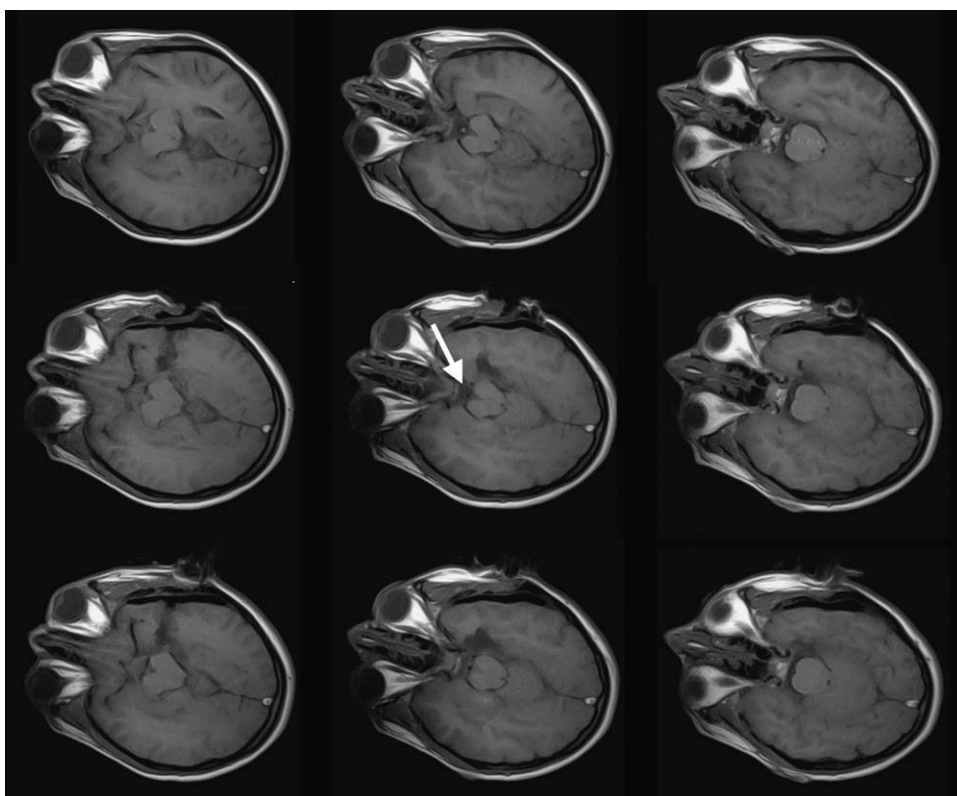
Surgical planning (*upper row*), interdissection (*middle row*), and quality assurance (*lower row*) T1-weighted MRI scans from a patient with intractable temporal lobe epilepsy. The surgical planning study shows the targeted amygdala and hippocampus. Unsuspected residual amygdala (*arrow*) was present on the interdissection study and was removed before the quality assurance study.
